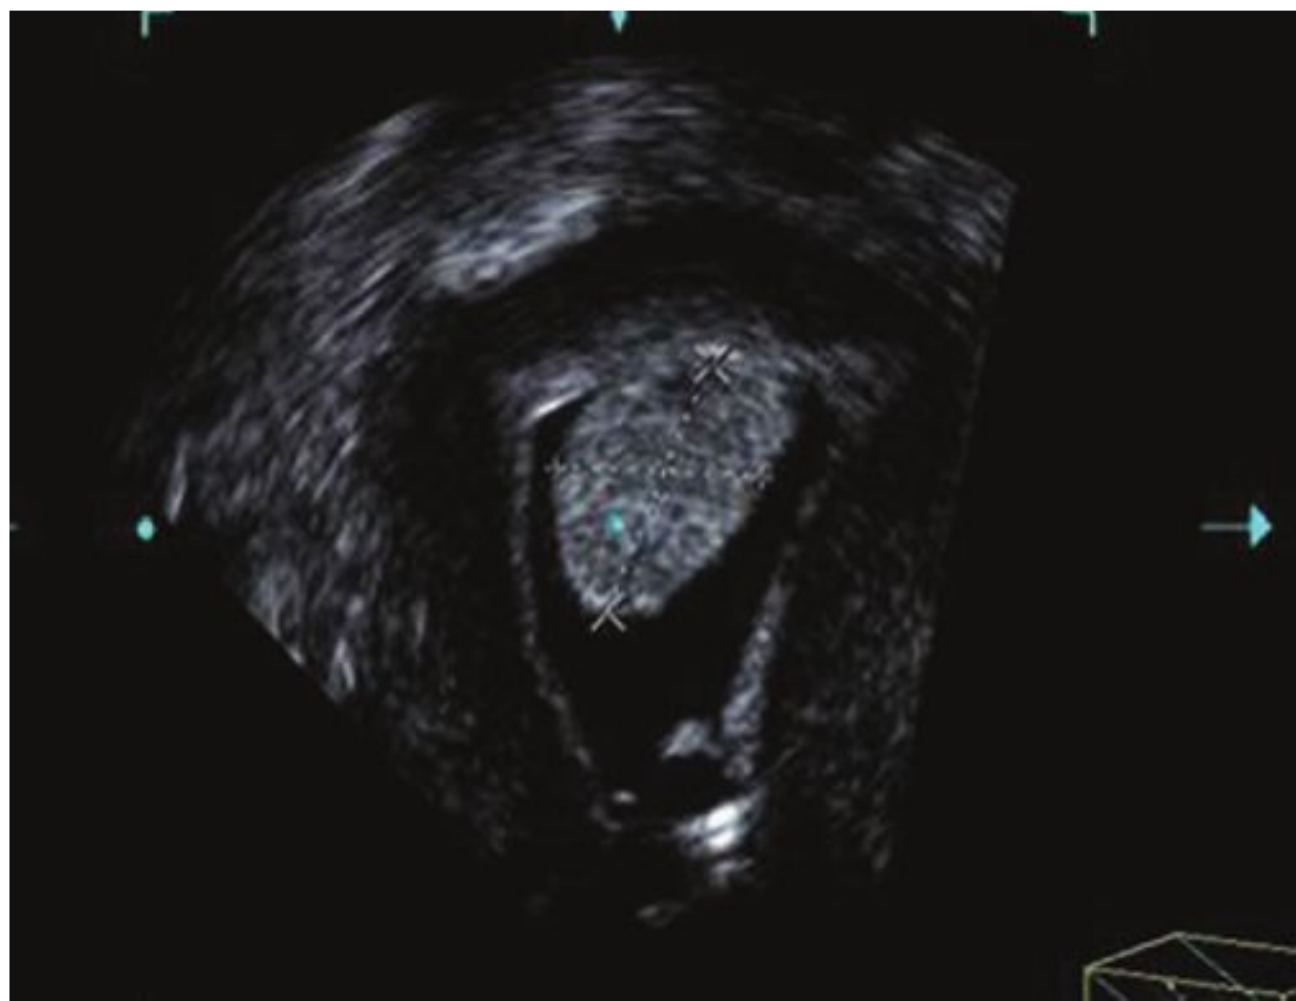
Three-dimensional image in the coronal plane of a polyp (calipers) after instillation of saline during saline infusion sonography.
